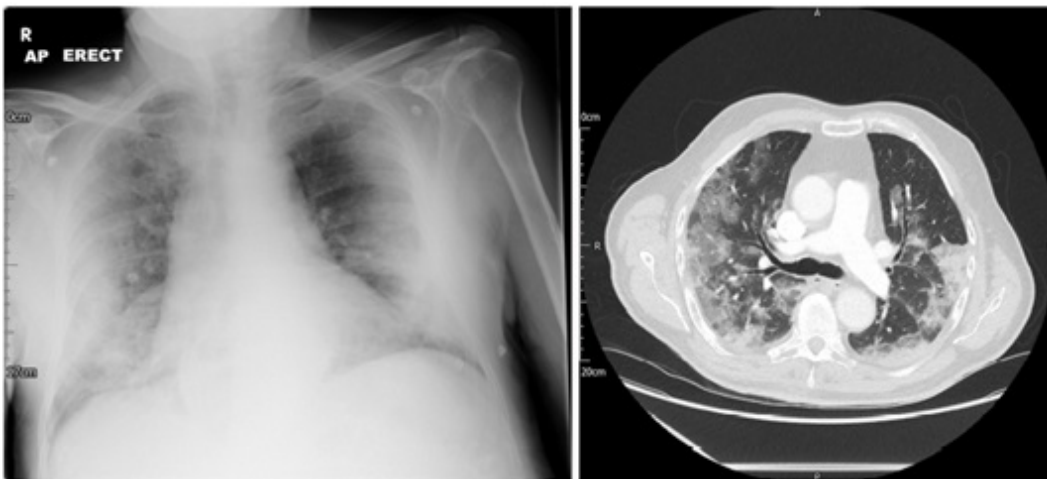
Chest X-ray and simultaneous thoracic tomography of a patient with severe COVID-19 who eventually developed RF. Multifocal ground glass opacities and consolidations are visualized.
